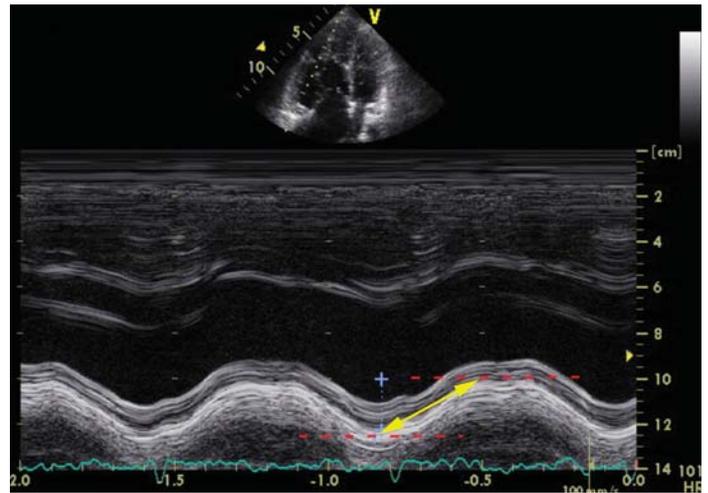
Measurement of tricuspid annular excursion by M-mode in the apical 4-chamber view. M-mode will be positioned in the lateral tricuspid valve annulus. The systolic excursion of the annulus toward the apex will be measured (+). In systole the tricuspid annulus will normally move toward the apex 1.5-2.0 cm.
